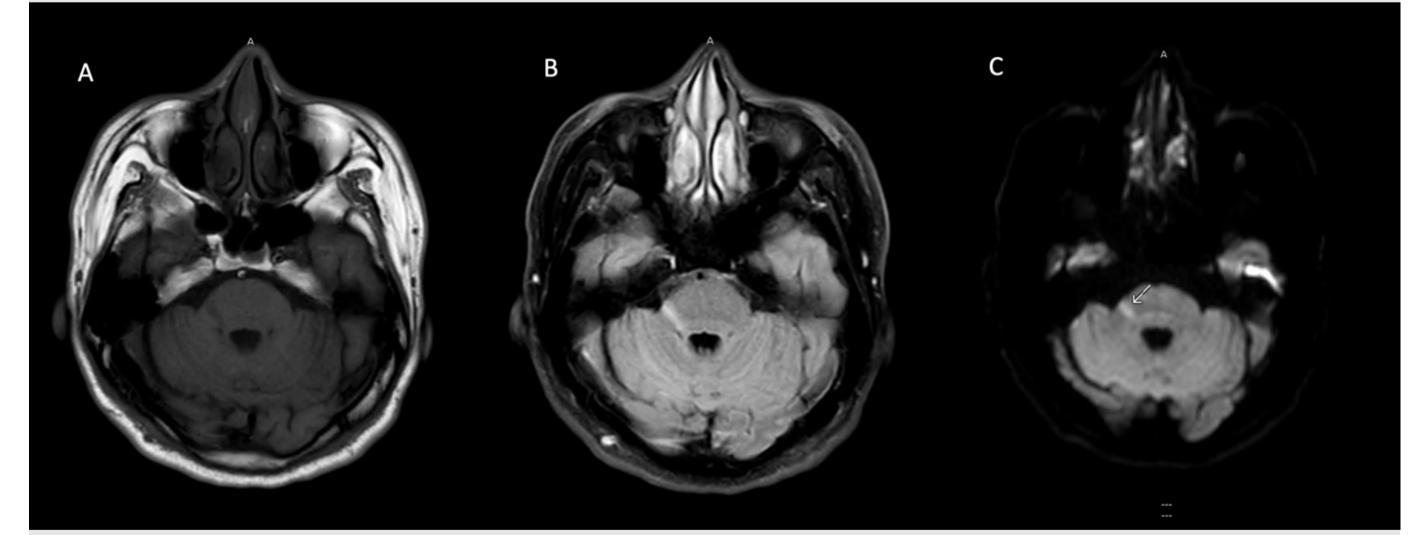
shows magnetic resonance imaging of the brain in the second case report, demonstrating a triangular, hypointense lesion on T1W imaging and hyperintense on T2W FLAIR at the right lateral aspect of the pons (A, B) with restricted diffusion-weighted imaging (C).
